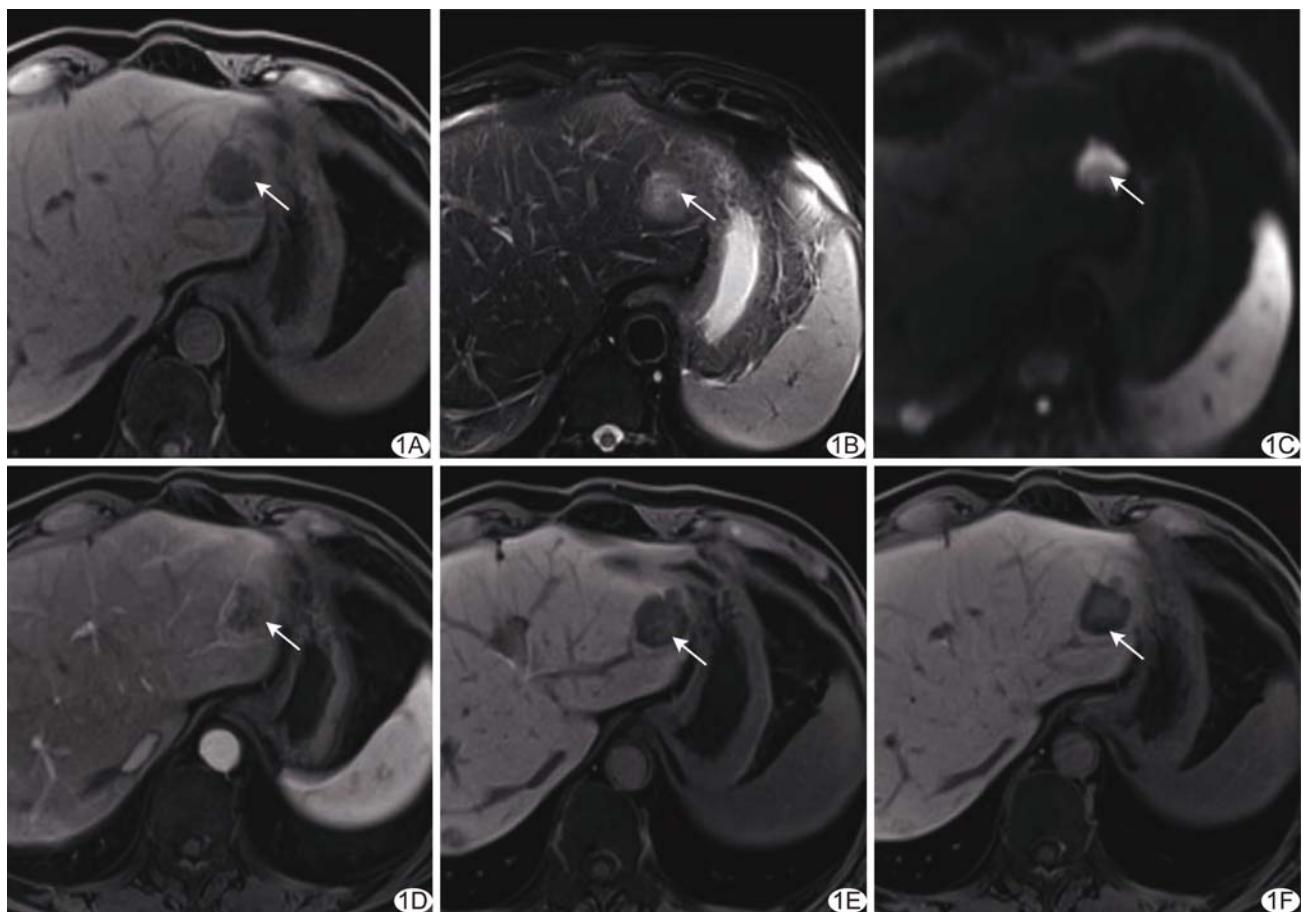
患者男,64岁,结直肠癌肝转移癌 A. MR T1WI 示肝 S2段低信号病灶; B. T2WI 呈高信号; C. DWI 呈高信号; D. 动脉期呈环形强化; E.F. 延迟期(E)及肝胆期(F)病灶边缘对比剂廓清,内部呈高信号,呈靶样强化(箭示病灶)
